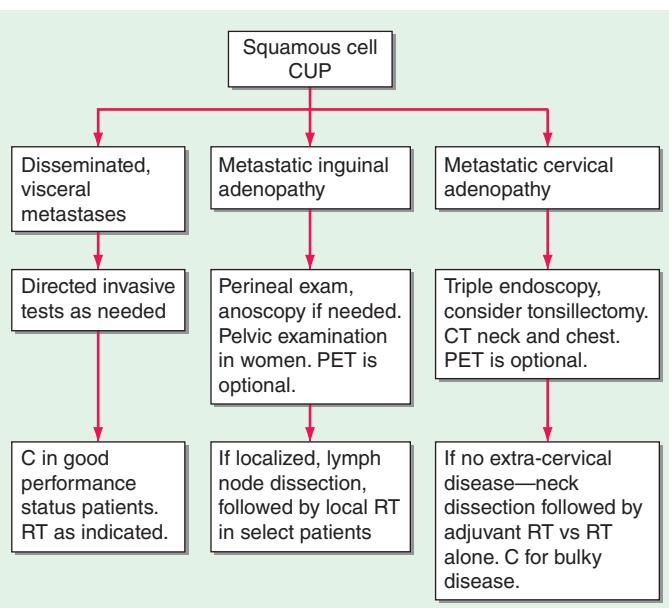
Treatment algorithm for squamous cell carcinoma of unknown primary (CUP). C, chemotherapy; CT, computed tomography; PET, positron emission tomography; RT, radiation.
